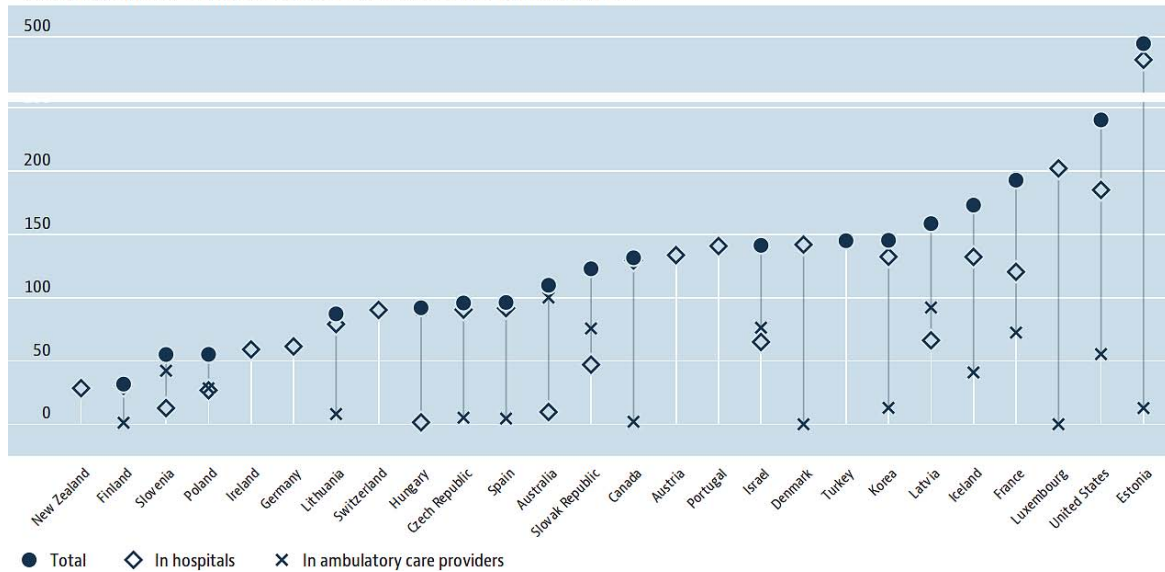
OECD figures for Computed Tomography (CT) exams (2013).
